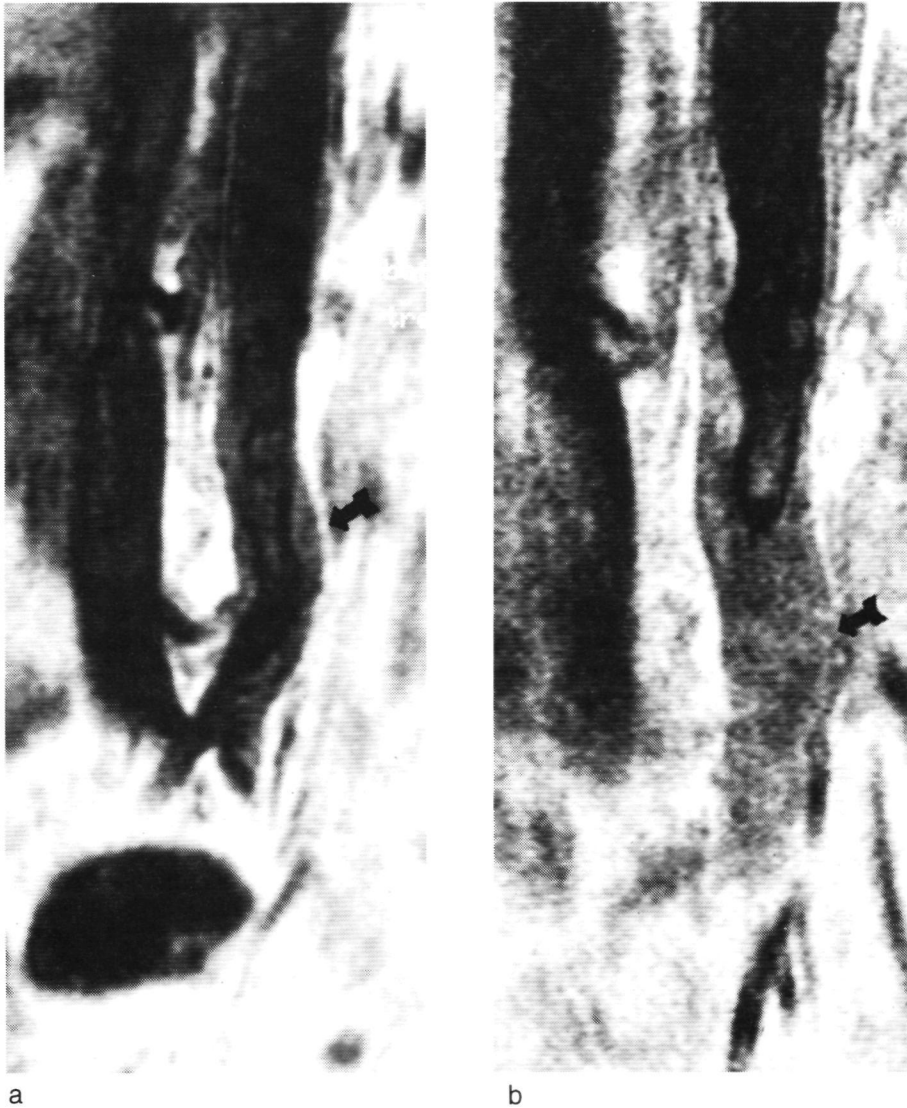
2b. A female 46 year old patient showed severe arteriosclerotic damages on the baseline MRI (Figure 13.2a) with arteriosclerotic plaques to 60% in the abdominal aorta and left common iliac artery. After two years of placebo-treatment (Figure 13.2b), the vascular damages were such deteriorated that the abdominal aorta was occluded completely.
